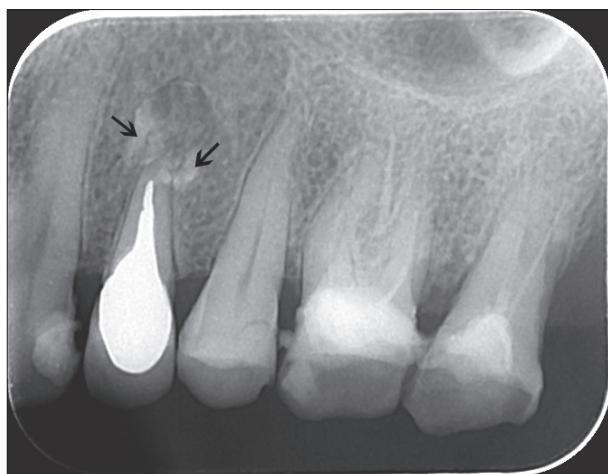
The radiograph of the upper right first premolar retrogradely obturated with mineral trioxide aggregate after removal of the cystic lesion (one week after the treatment); arrows show the material placed in the cystic defect surrounding the apex of the root.
